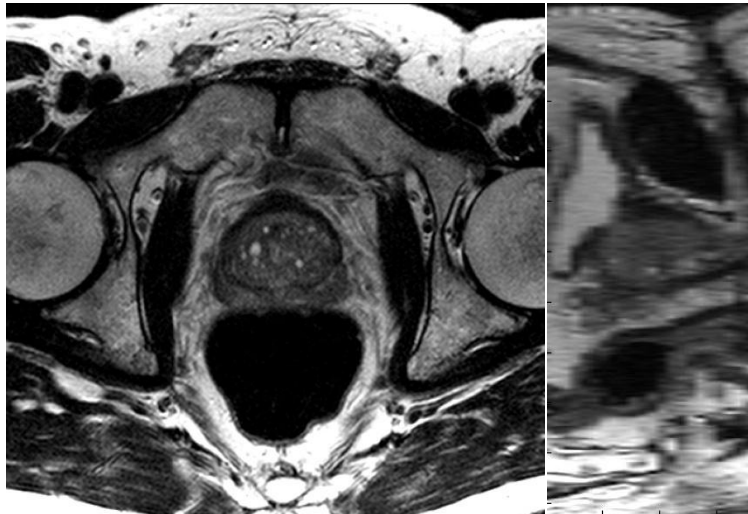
Example slices of a T2 MR image of prostate. Left: the transverse view and, right: the sagittal view
